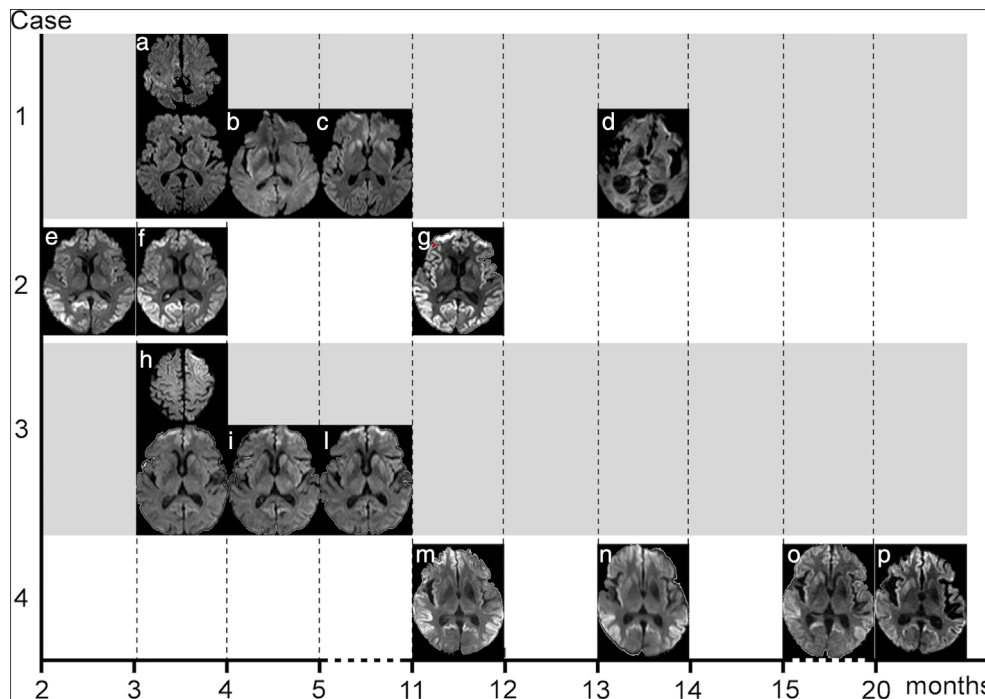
The other four long-lasting CJD cases previously studied⁹ with longitudinal 1.5 T MRIs (DWI). Case 1: At onset: memory impairment; after 3 months (a) mini mental state examination (MMSE) = 24; after 4 months (b,c) progressively worsening dystonia, myoclonus, dysphagia, mutism; after 13 months (d) vegetative state Glasgow Coma Scale (GCS) = 5; after 14 months: exitus. PrPSc type 1, PRNP gene 129 codon methionine-methionine (MM) Case 2: At onset: apraxia, memory impairment, obsessive behavior; after 2 months (e) mini mental state examination (MMSE) = 18, mild extrapyramidal signs and ataxia, after 3 months (f) dysphagia, myoclonus, anarthria, after 11 months (g) Glasgow Coma Scale (GCS) = 9, after 16 months: exitus. PrPSc type 2, PRNP gene 129 codon MV Case 3: At onset: depression; after 2 months: disorientation, memory impairment; after 3 months (h) gait impairment; after 4 months (i,l) myoclonus and severe dysphagia, after 9 months: exitus. PrPSc type 1, PRNP gene 129 codon methionine-methionine (MM) Case 4: At onset: decreased verbal output, after 13 months: global aphasia, after 15 months: global cognitive deterioration, after 20 months: extrapyramidal signs, myoclonus, mutism, after 22 months: exitus.
